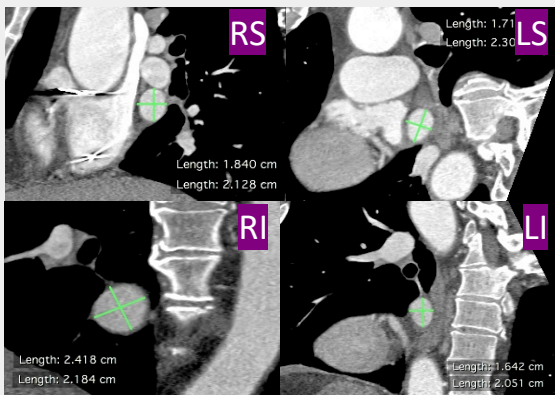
Contrast cardiac CT images showing measurement of mean PV ostial diameters using multiplanar reformation.
